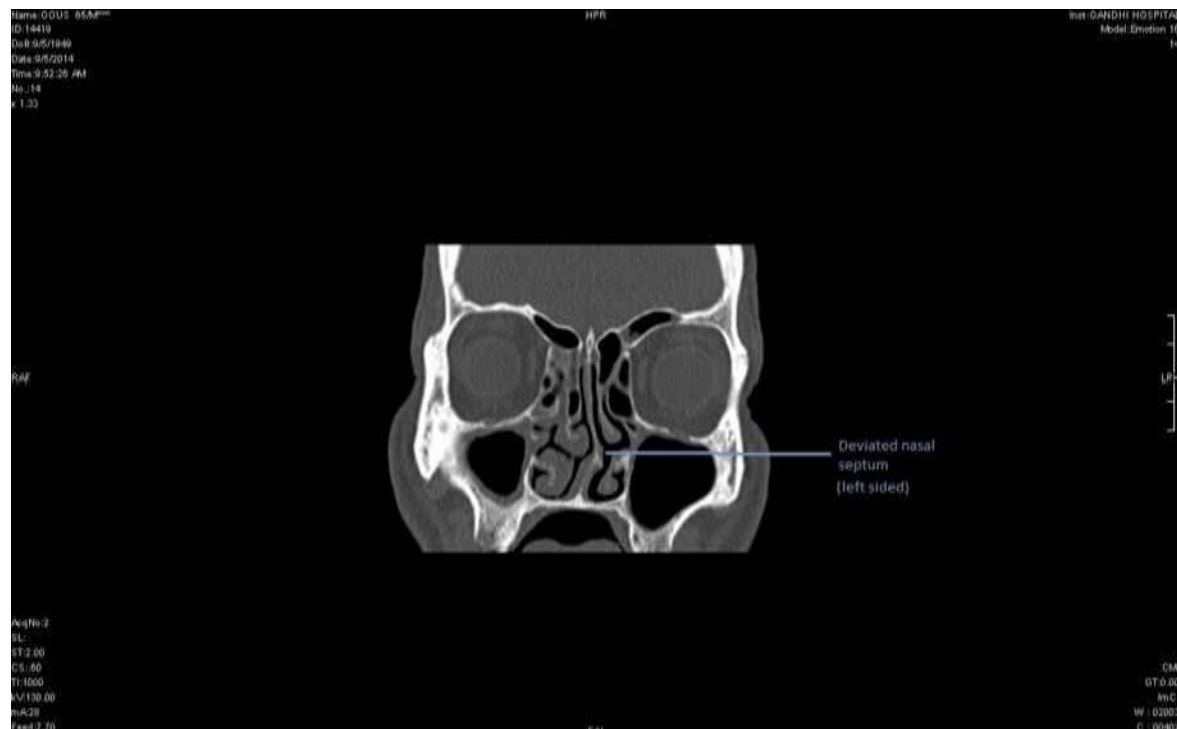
CT scan of Paranasal sinuses showing left sided deviated nasal septum
